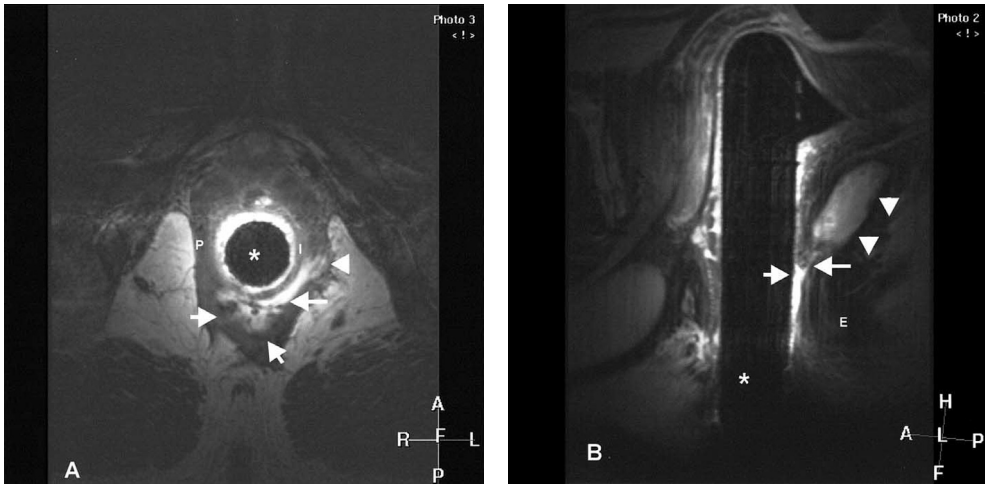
Intersphincteric abscess. (A) Axial T2-weighted fast spin echo (FSE) endoanal MR image (TR/TE = 2500/100 ms). Circumferential spread of fistula to the left (long arrow) predominantly within the intersphincteric space; also small extension of fistula is seen within the puborectalis muscle (arrowhead). In the midline posteriorly, local widening of the fistula (arrows) can be seen in the intersphincteric space, indicative of an abscess. I, internal anal sphincter; P, puborectalis muscle. (B) On the mid-sagittal T2-weighted FSE (TR/TE = 2454/100 ms) image the abscess can clearly be demonstrated (arrowheads). Note that part of the fistula (arrow) with an internal opening in the anal canal (small arrow) can also be seen on this slice. E, external anal sphincter; endoanal coil (*).
